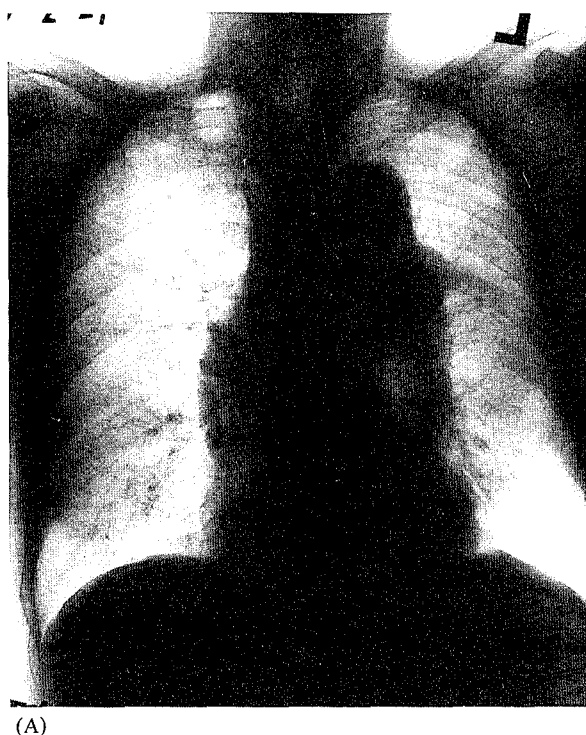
(A) Chest X-ray shows an upper left lung mass.
